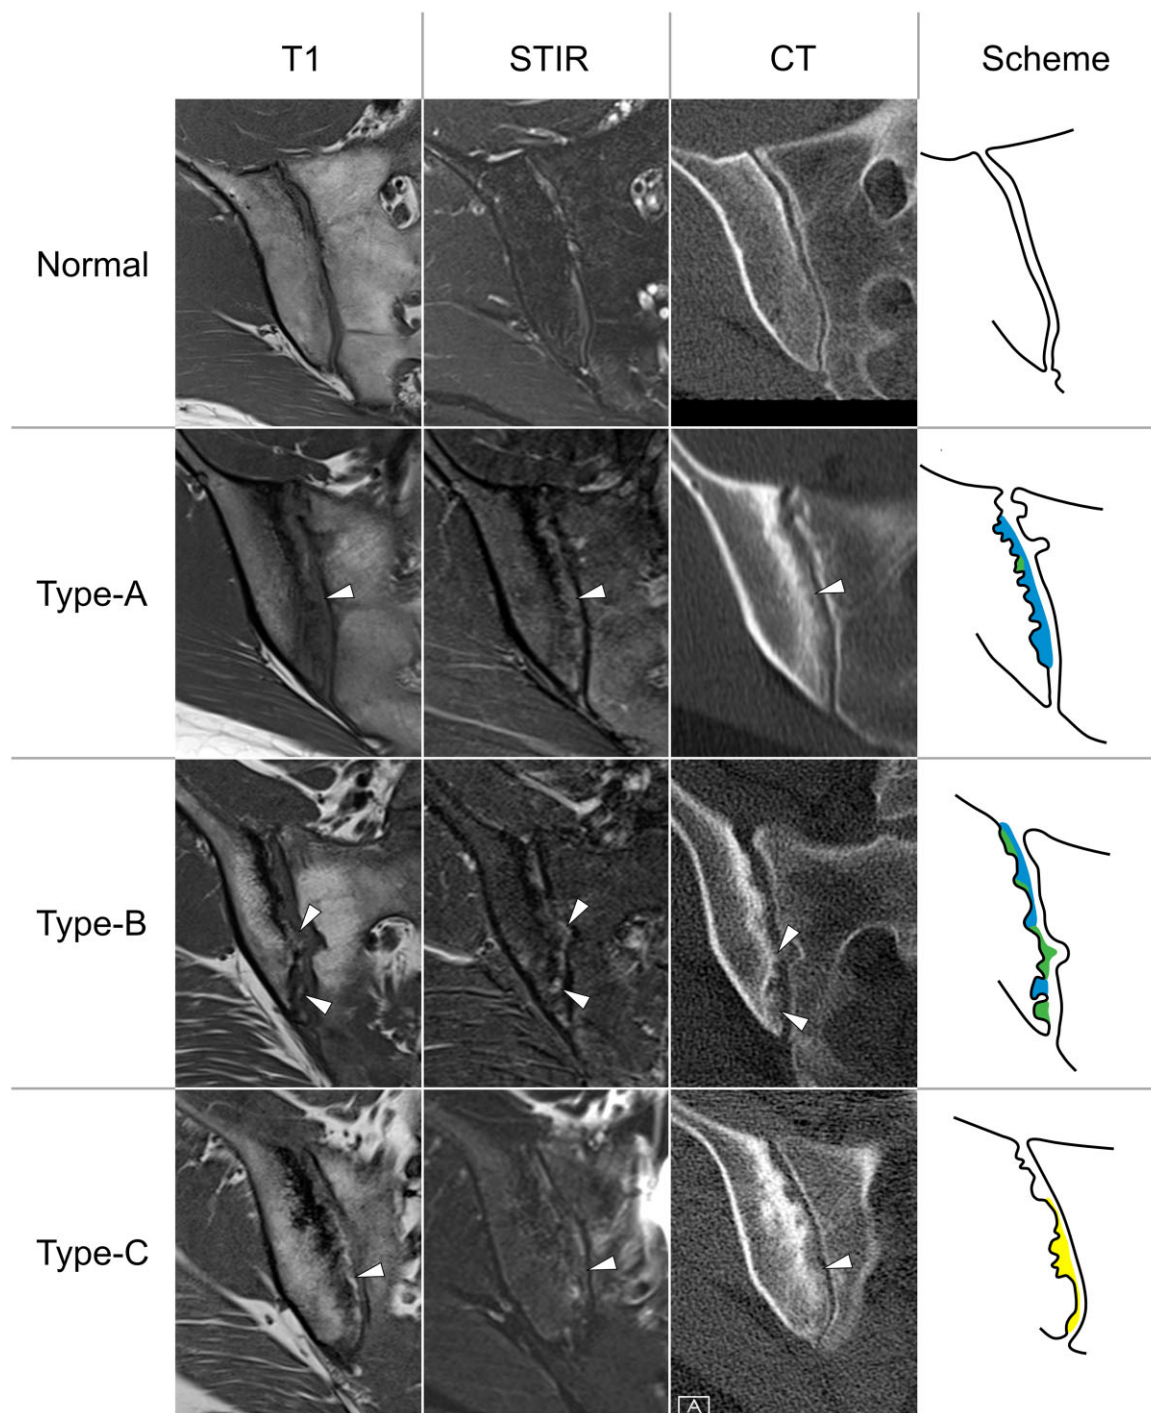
Different types of joint space lesions on MRI and CT. All lesions (arrowheads) show faint bone matrix calcifications, irrespective of their imaging characteristics on MRI
